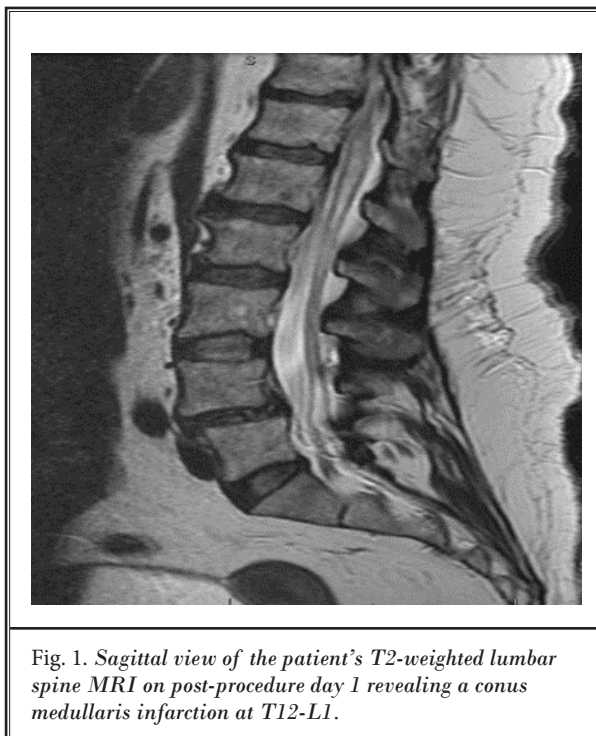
Sagittal view of the patient's T2-weighted lumbar spine MRI on post-procedure day 1 revealing a conus medullaris infarction at T12-L1.
